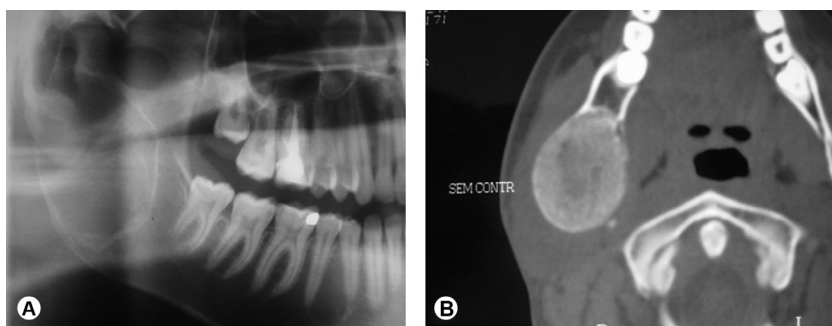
Case 6. A: Well-delimited large radiolucent image located in the right mandibular ramus. B: CT scan showing well-circumscribed mixed image.
